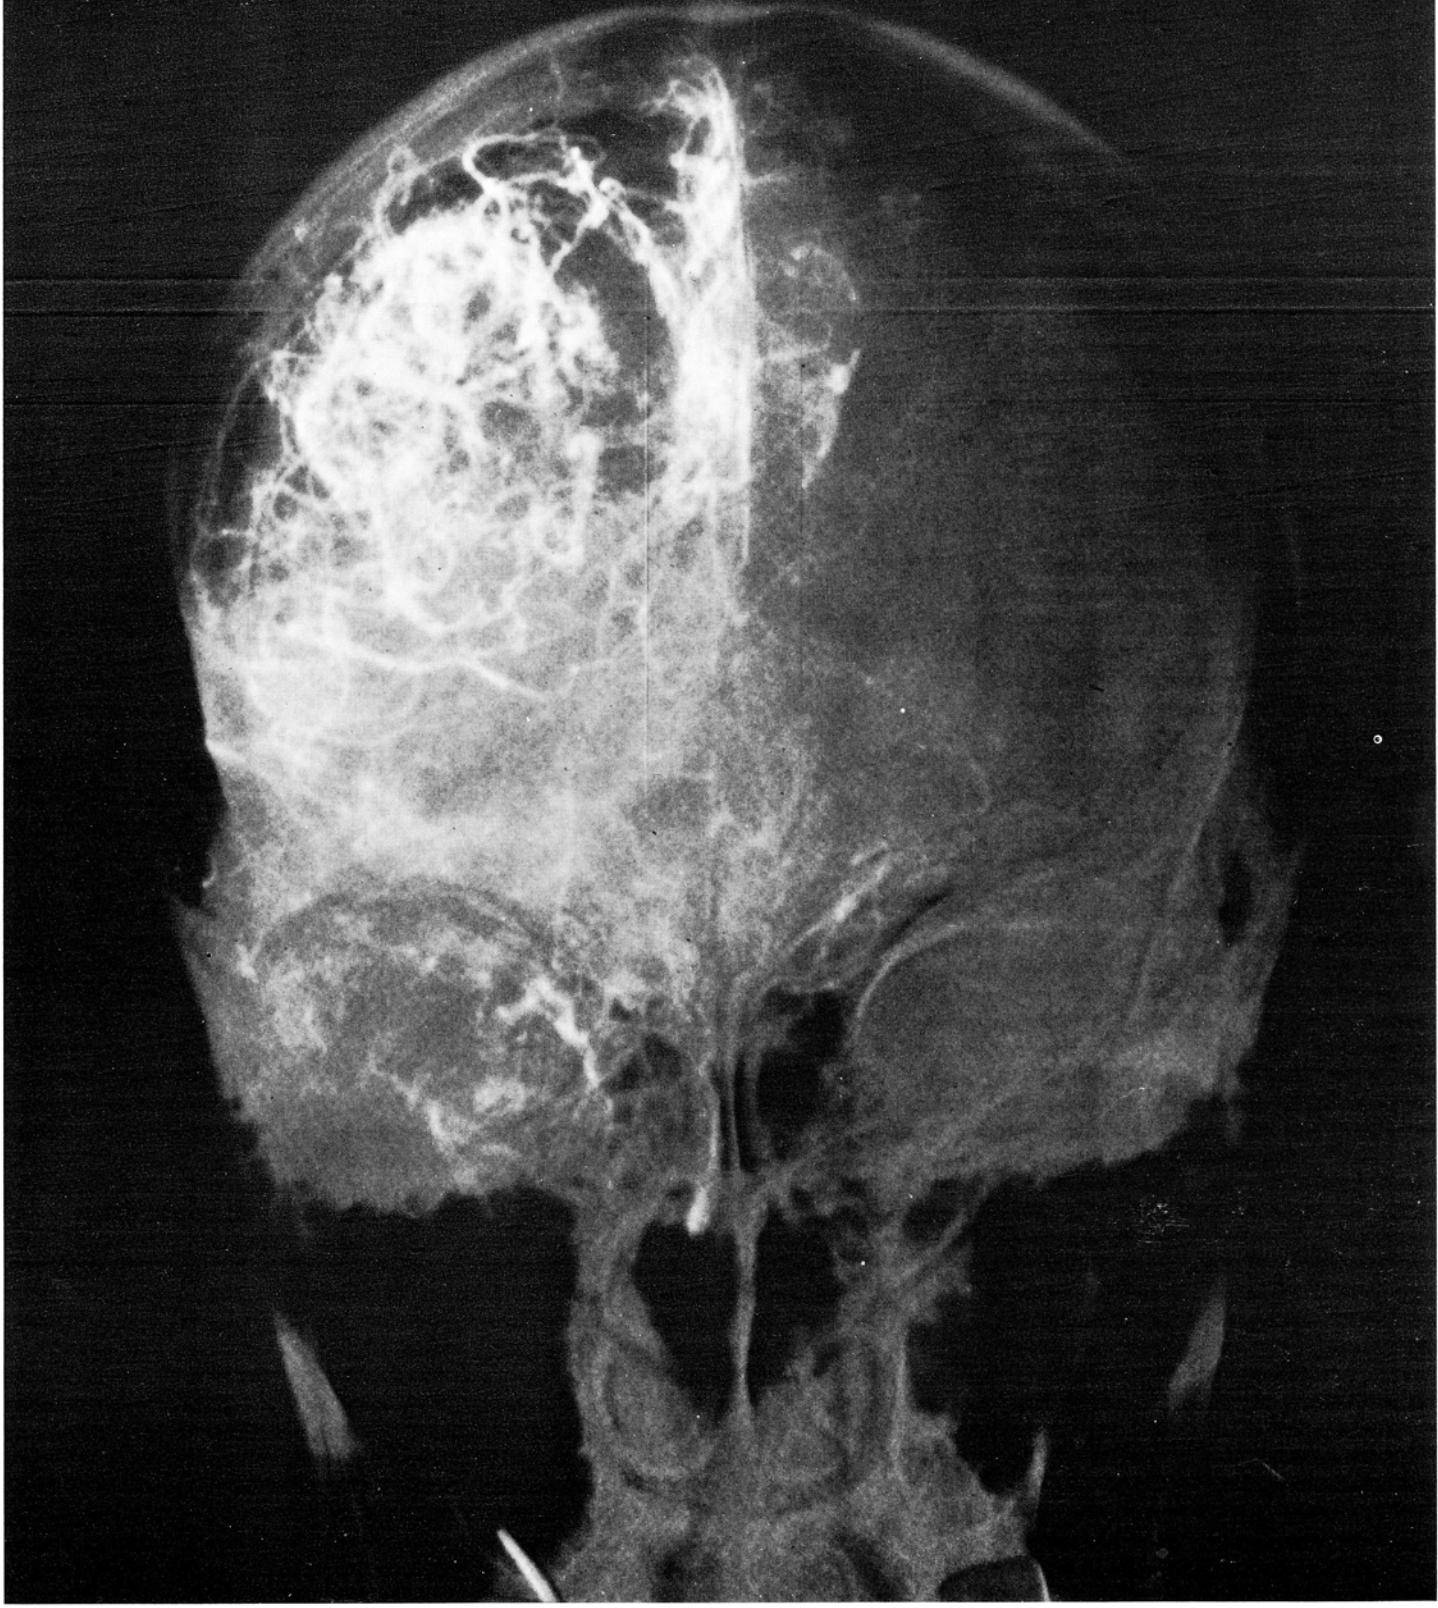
Subtraction roentgenogram of carotid angiogram in arterial phase showing large tortuous vascular structures in parietal area.
